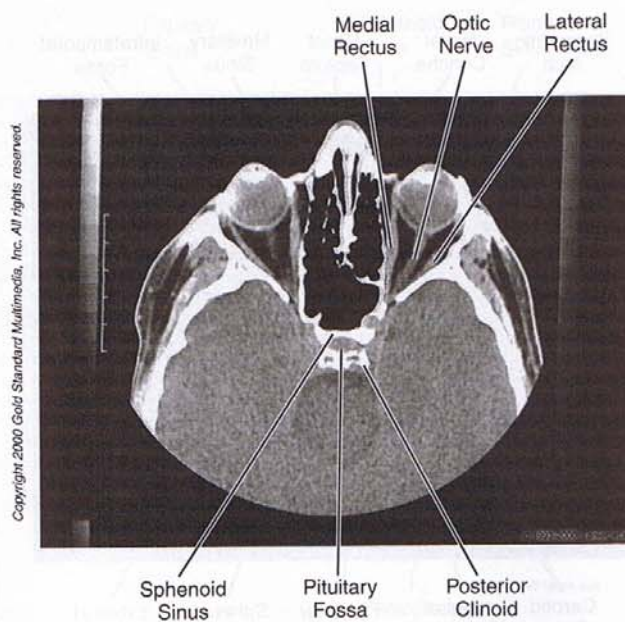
Head and Neck: CT, Orbit
